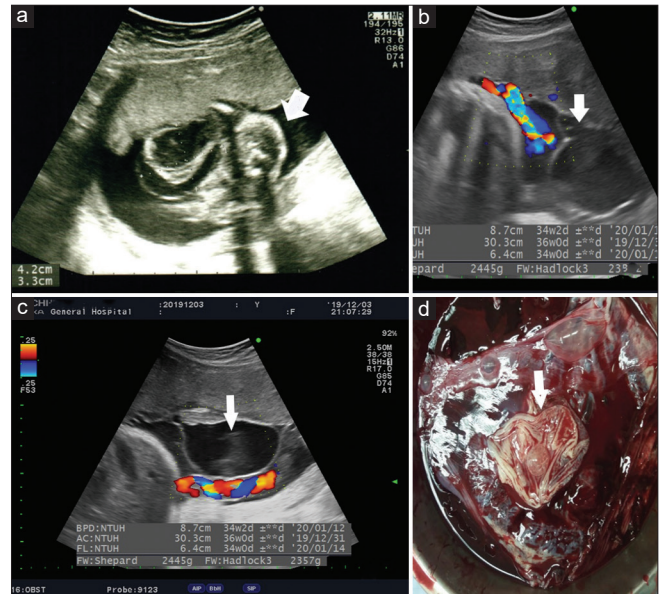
At the 19th week, a cyst-like lesion measured about 42 mm behind the fetal neck (arrow) (a). At 34 gestational weeks, an ultrasound revealed an independent placenta cyst measured 75 mm × 65 mm in diameter (arrow) (b and c). After delivery, a placenta cyst (arrow) was noted (d)
